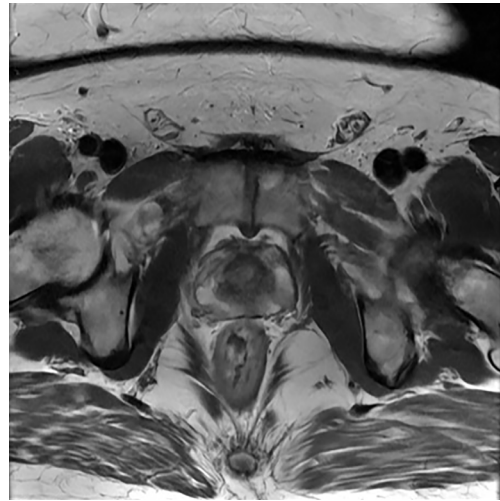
MRI abdomen/pelvis, 4 months post-resection of the diagnostic TURBT, showing nonspecific right bladder neck wall enhancement, but without infiltration into perivesical fat, pelvic lymphadenopathy, or osseous metastatic disease. MRI, magnetic resonance imaging; TURBT, transurethral resection of bladder tumor.
